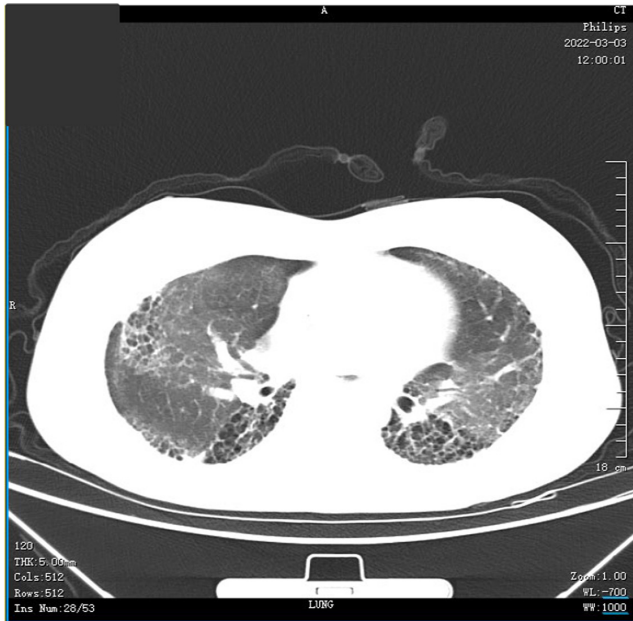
Repeat chest computed tomography examination displaying greatly improved bilateral pulmonary infiltrations and opacities.
